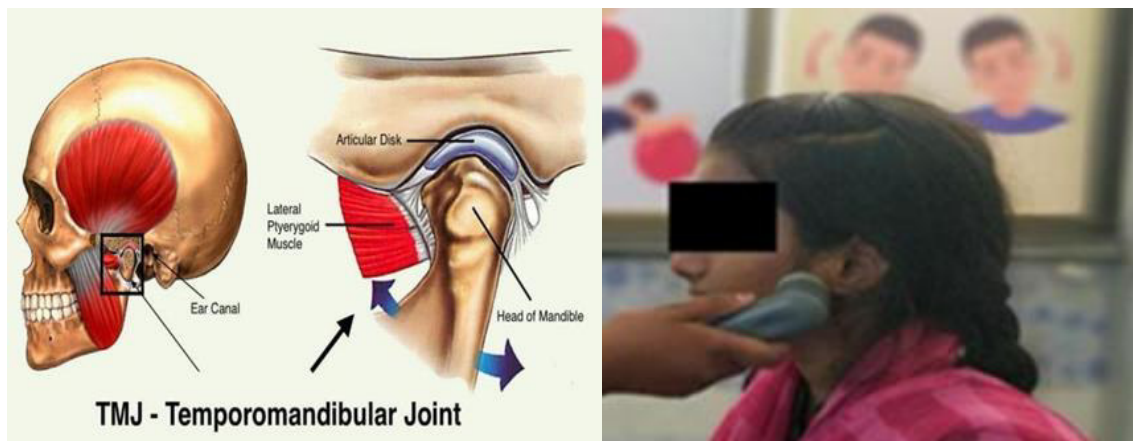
Temporomandibular Joint structure and Ultrasound Therapy given to left side Temporomandibular Joint of subject involved in the study.
